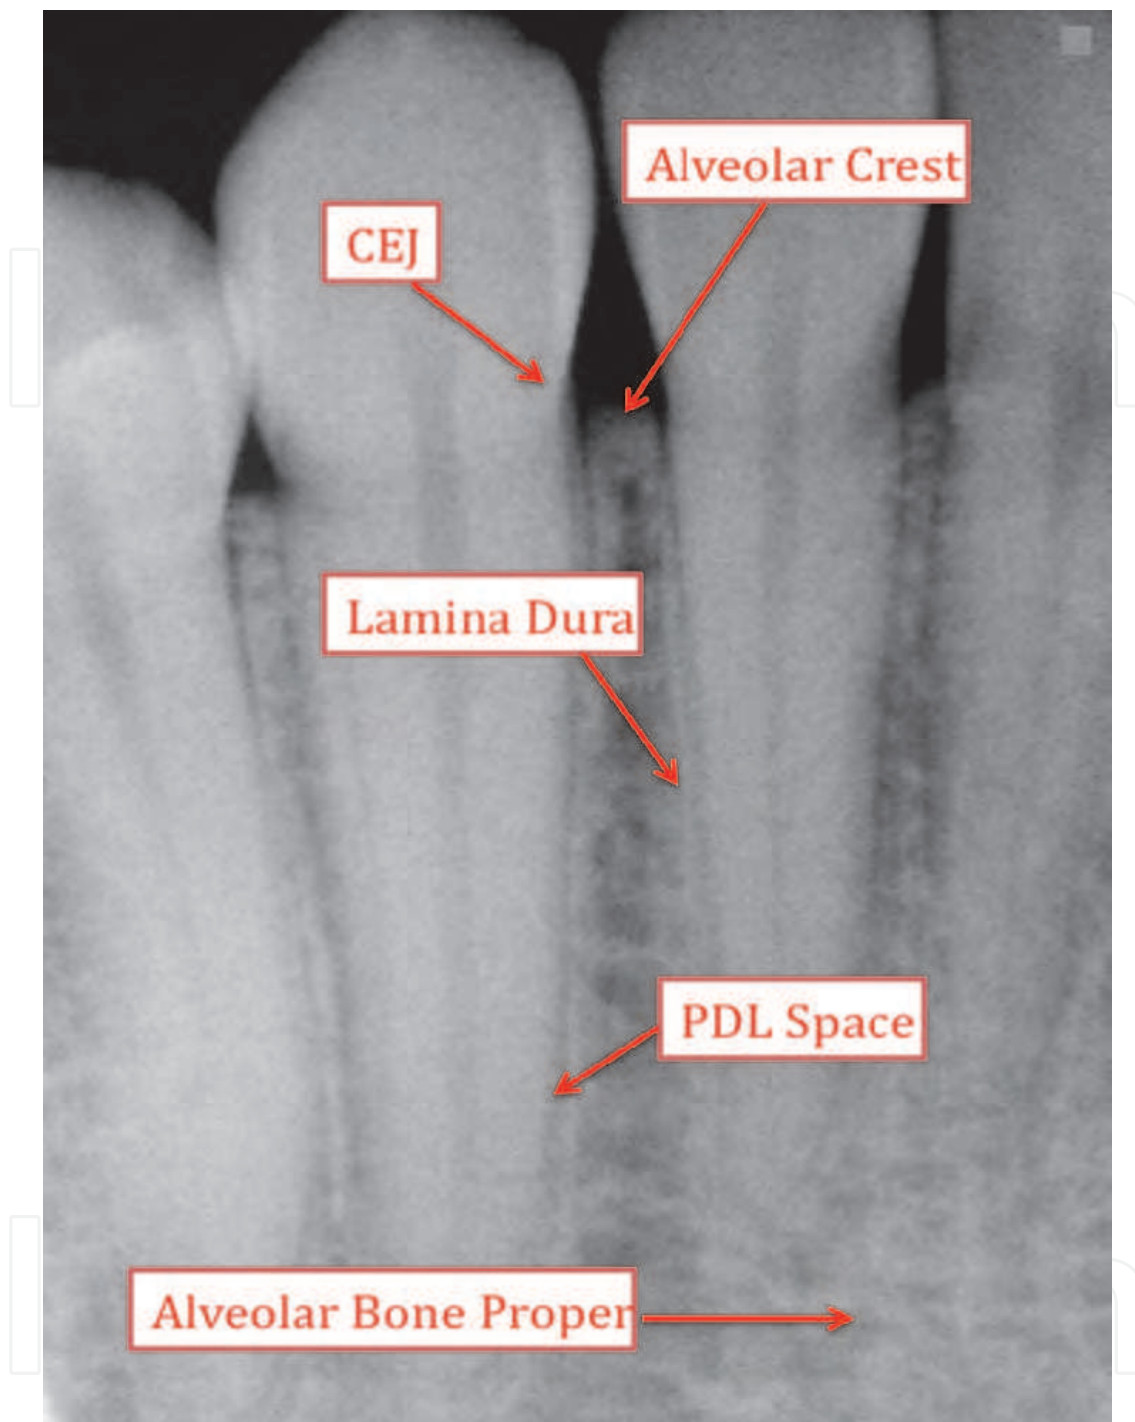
Appearance and location of periodontal components on a periapical radiograph
